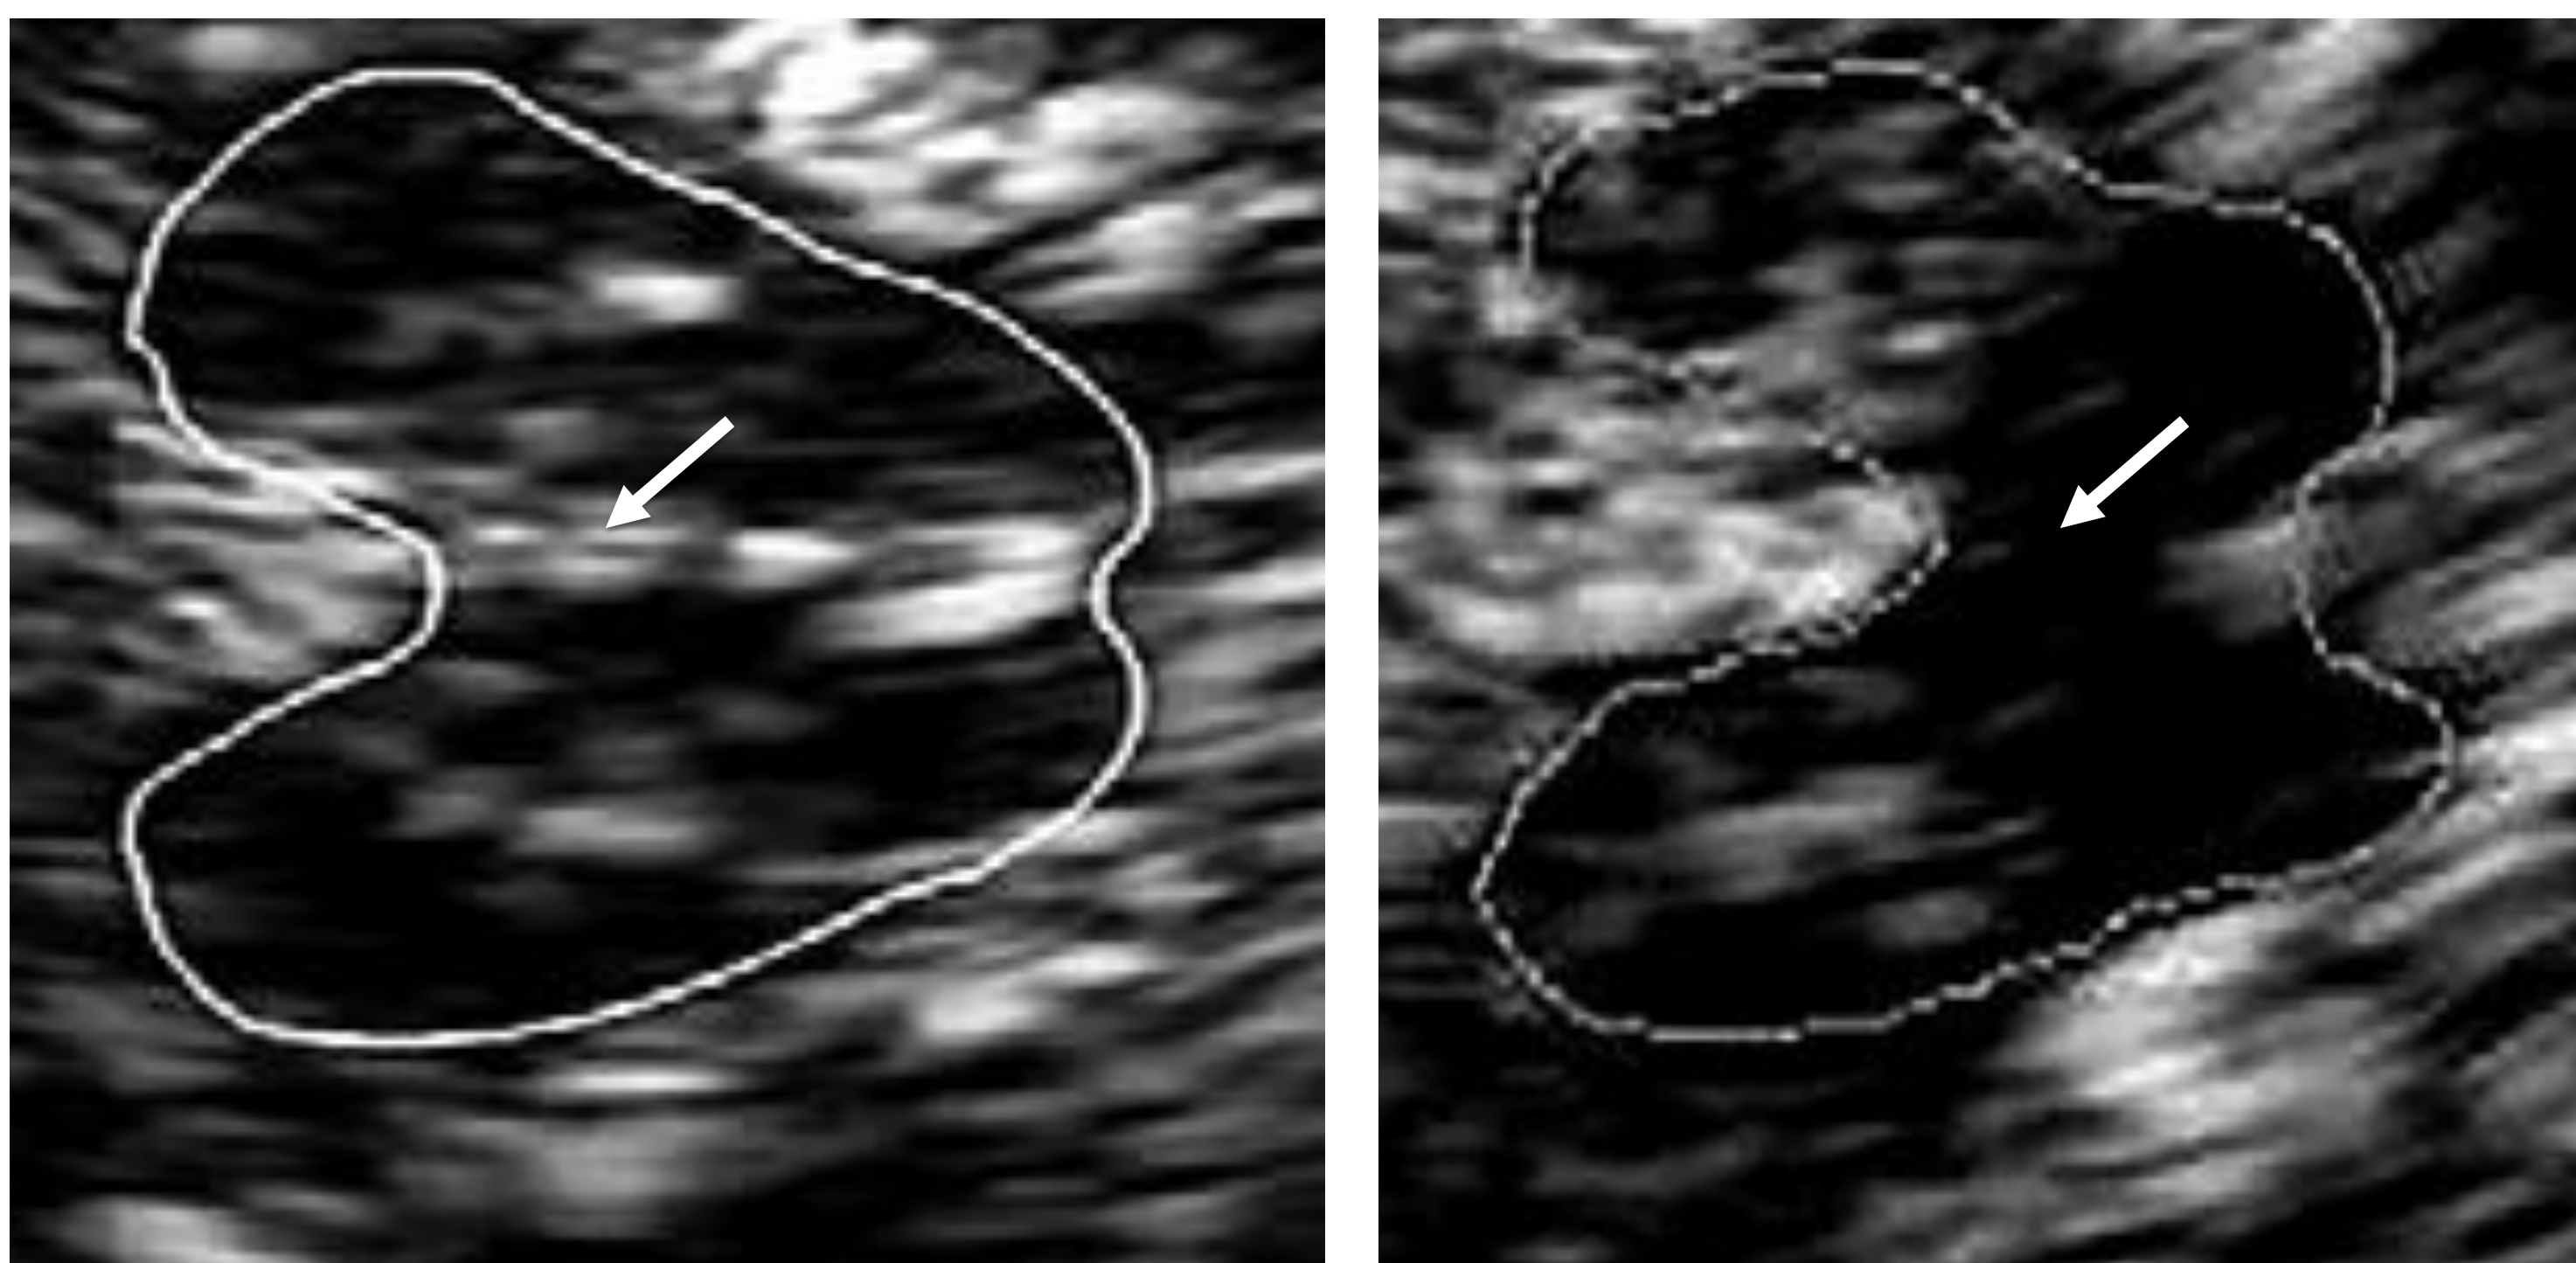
Transcranial sonogram (zoom) of brainstem continuous midline raphe from a PD patient without depression (left) and an absent brainstem midline raphe from a PD patient with depression (right). Location of the midline raphe is depicted with an arrow. The echogenic region of the mesencephalon is encircled for better visualization.
